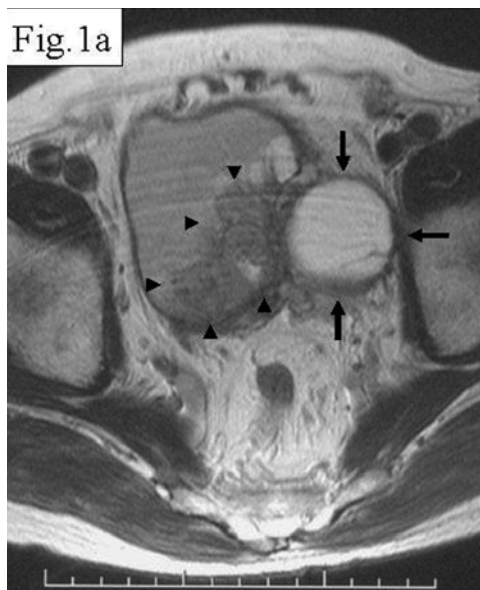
MRI findings. (a) Large cysts (arrows) and irregular tumor (arrow heads) involving the left side of the urinary bladder. (b) Large cysts (arrows) and irregular tumor (arrow heads) involving the left side of the prostate gland.
